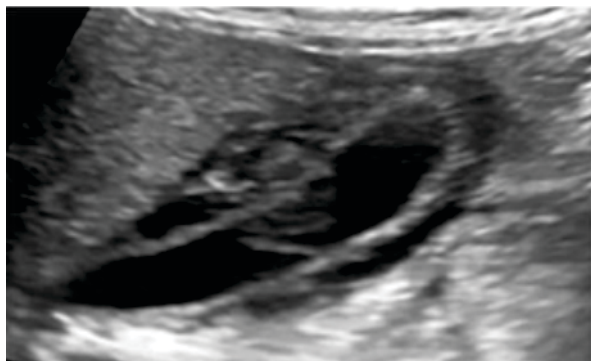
Ultrasound appearance of an asymmetric pattern (echogenic tissue projecting into the gall bladder lumen).
